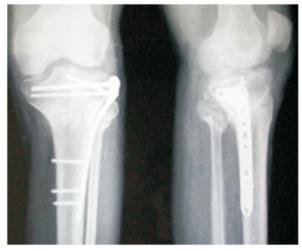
Radiograph at twelve weeks showing malunion
